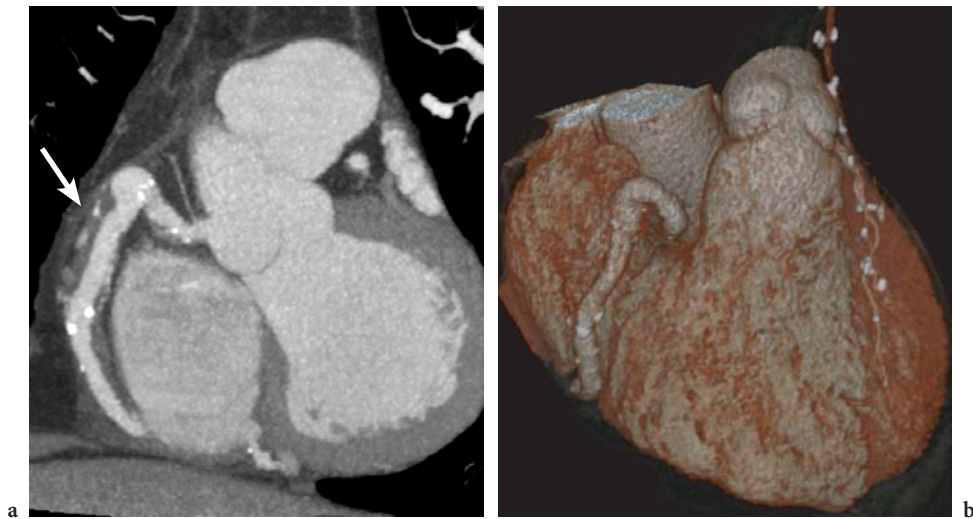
16-slice CT examination of an aneurysm of the proximal RCA with extended thrombotic changes of the vessel wall. Displayed with thin-MIP projection (a) and volume-rendering reconstruction (b). The thrombus is visualized with thin-MIP (arrow in a). It is not shown in VRT display (b) but note a left IMA bypass to the distal LAD
